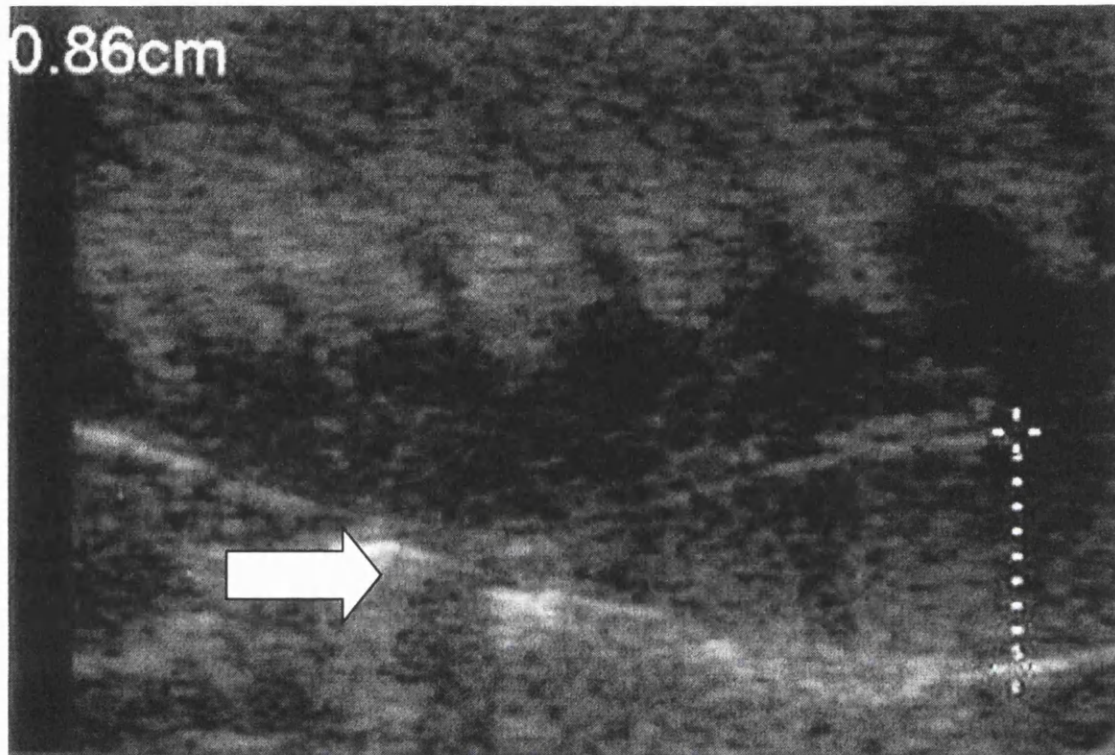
An ultrasound image of a gonad, with the width measurement and end highlighted with the arrow, of an immature Atlantic salmon from the May 2003 sample.
